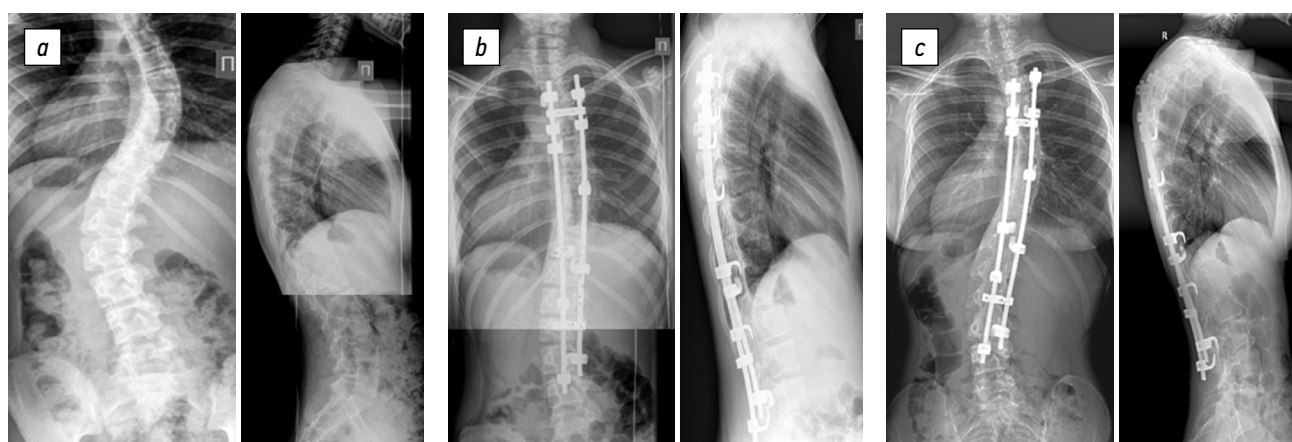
Radiographs of an 11-year-old female patient in two views: *a* — preoperative image of degree IV right-sided thoracic scoliotic deformity (42° according to Cobb), with thoracic kyphosis of 25° and lumbar lordosis of 60°; *b* — surgical correction of scoliotic deformity of the spine using laminar fixation without ventral intervention resulted in the main thoracic curve of 12°, thoracic kyphosis of 13°, and lumbar lordosis of 48°; *c* — X-ray control 1 year after the surgery revealed the main thoracic curve of 46°, thoracic kyphosis of 21°, and lumbar lordosis of 54°
